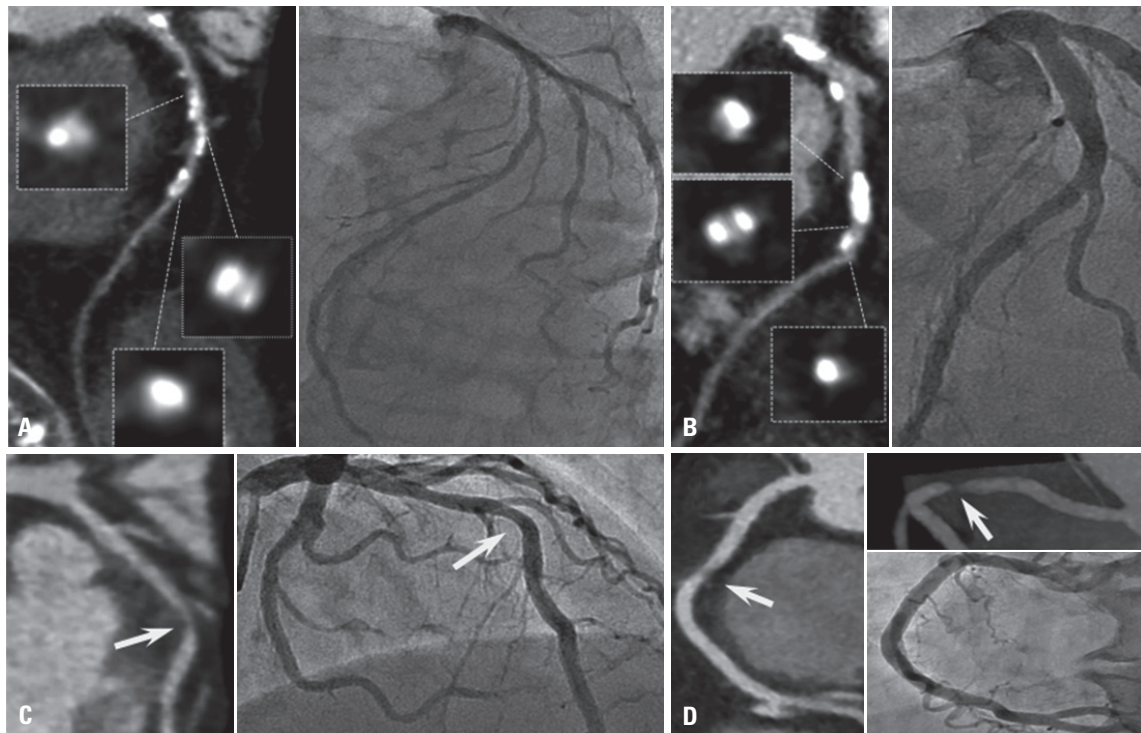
Representative false positive cases for needing revascularization based on the coronary computed tomographic angiography (CCTA). (A) CCTA falsely identified this patient as a candidate for revascularization, based on the diffuse calcification of left anterior descending artery (LAD). (B) A second false-positive was indicated for revascularization because of a heavily calcified lesion within the LAD. (C) LAD was falsely identified as requiring revascularization because of lesion severity overestimation (arrow). (D) This right coronary artery was falsely indicated for revascularization because of a motion artifact (arrow). Right images of each panel (A, B, and C) are CCTA and left images are conventional coronary angiography. In panel (D), right and left upper images are CCTA and left lower image is conventional coronary angiography.
